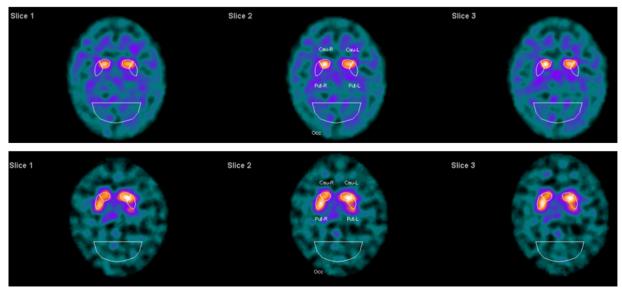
123 I-FP-CIT SPECT image of II-2 and III-1.
